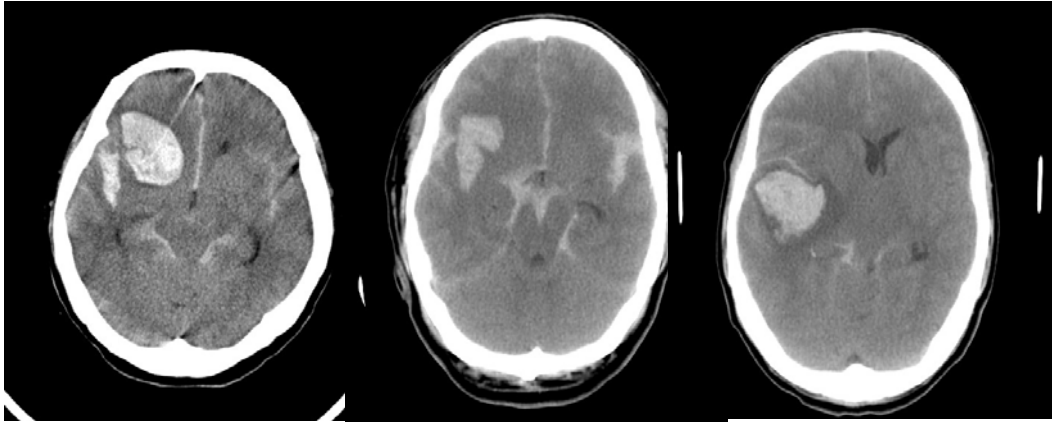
Type of ICH. Axial CT scans of preoperation. A: Temporal type ICH, B: Frontal type ICH, C: Sylvian type ICH(ICH : Intracerebral hemorrhage).
